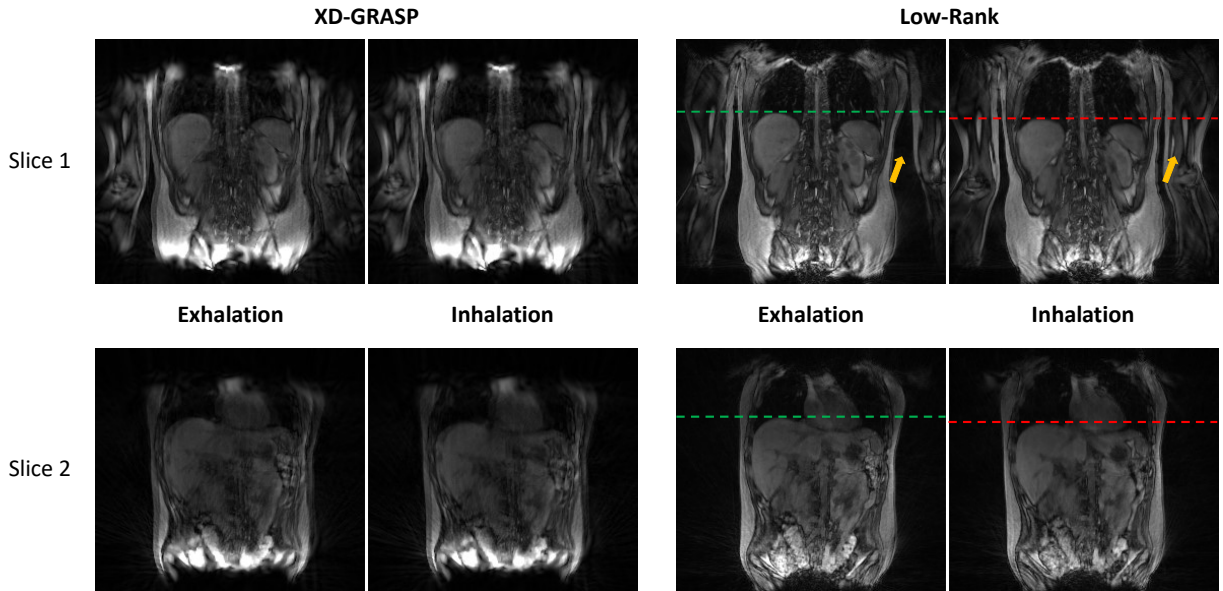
Representative MR images obtained with the XD-GRASP and the proposed method. The red dashed-line indicates the top of the liver position for end-inhalation and the green dashed-line indicates the top of the liver position for end-exhalation. Note that, besides respiratory motion, bulk motion indicated by the yellow arrows is clearly seen in the proposed low-rank based image reconstruction. The images obtained by XD-GRASP show blurring artifacts largely because the bulk motion was not detected from the navigator signal (see Figure 2.7 for more details).
